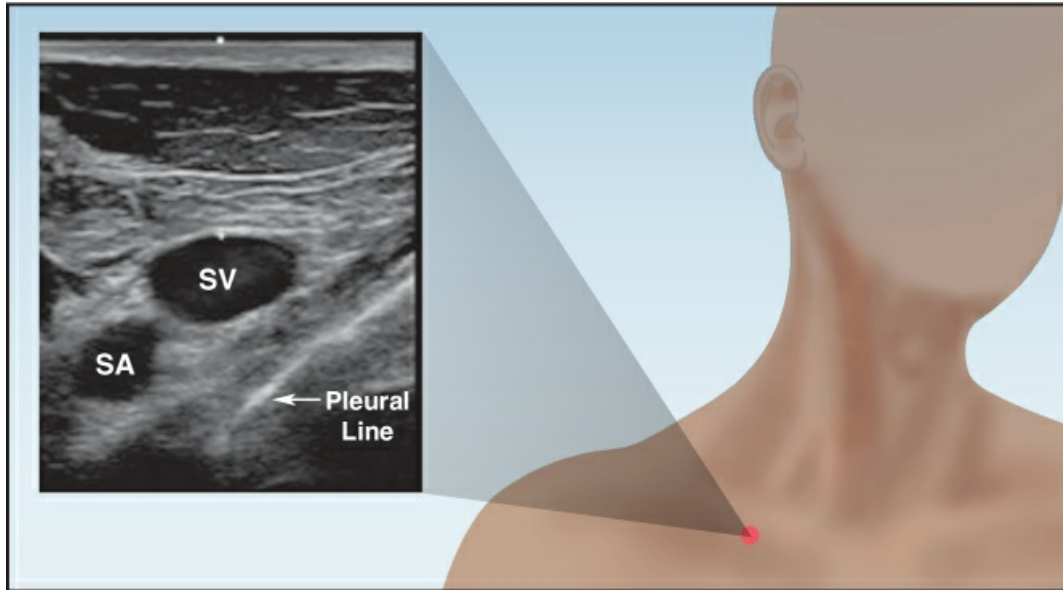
Infraclavicular, short-axis view of the subclavian vein (SV), subclavian artery (SA), and apical pleura, obtained by placing the ultrasound probe just below the clavicle in the region where it overlies the subclavian vein. See text for further explanation. Ultrasound image from Reference 25.
